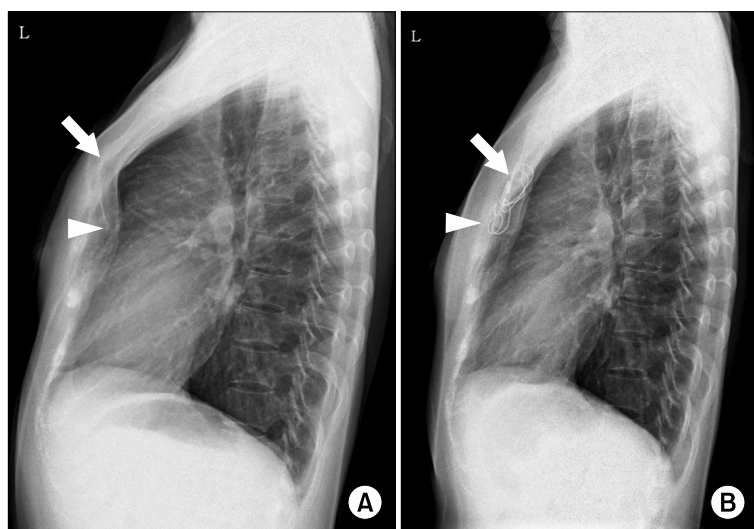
(A) Preoperative left lateral chest X-ray. Arrow: most convex point. Arrowhead: most concaved point. (B) Six-month postoperative left lateral chest X-ray. Arrow: wedge-osteotomy site was stabilized with vertical wiring. Arrowhead: partial osteotomy with bone segment implantation site was stabilized with vertical wiring.
